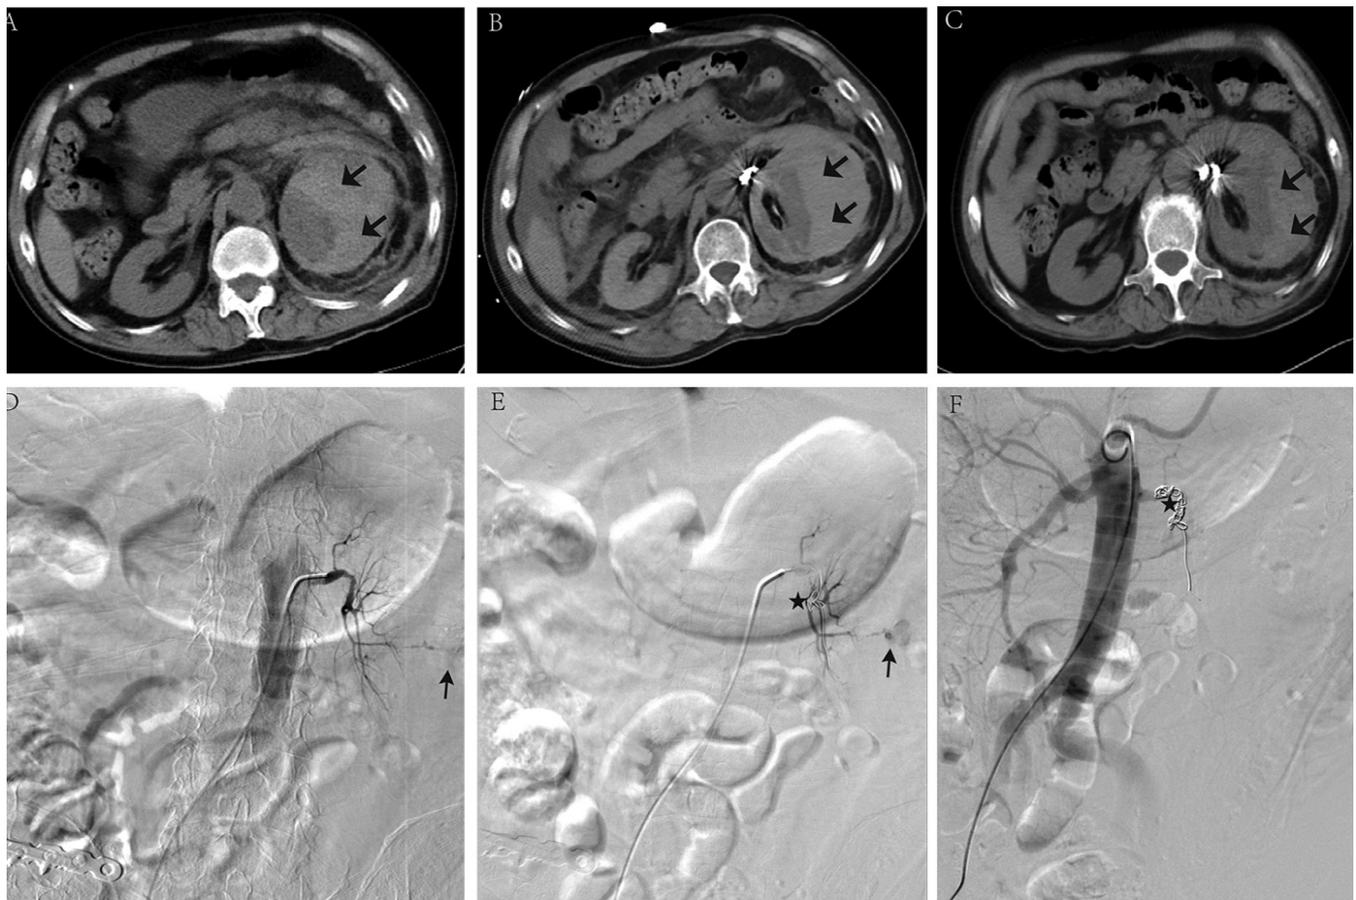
A, B, and C are abdominal CT scans of the patient: A shows the image before left renal artery embolisation; B shows the image on the second day after the procedure; C shows the image one week after the procedure. The arrows indicate the bleeding sites. D, E, and F are angiographic images: D shows the image before arterial embolisation; E shows the image during the procedure; F shows the image after the procedure. The arrows indicate extravasated contrast medium, and the pentagrams indicate the embolisation coils.
